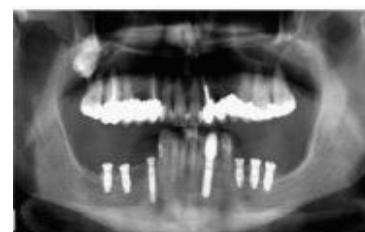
CT scan after implants insertion
